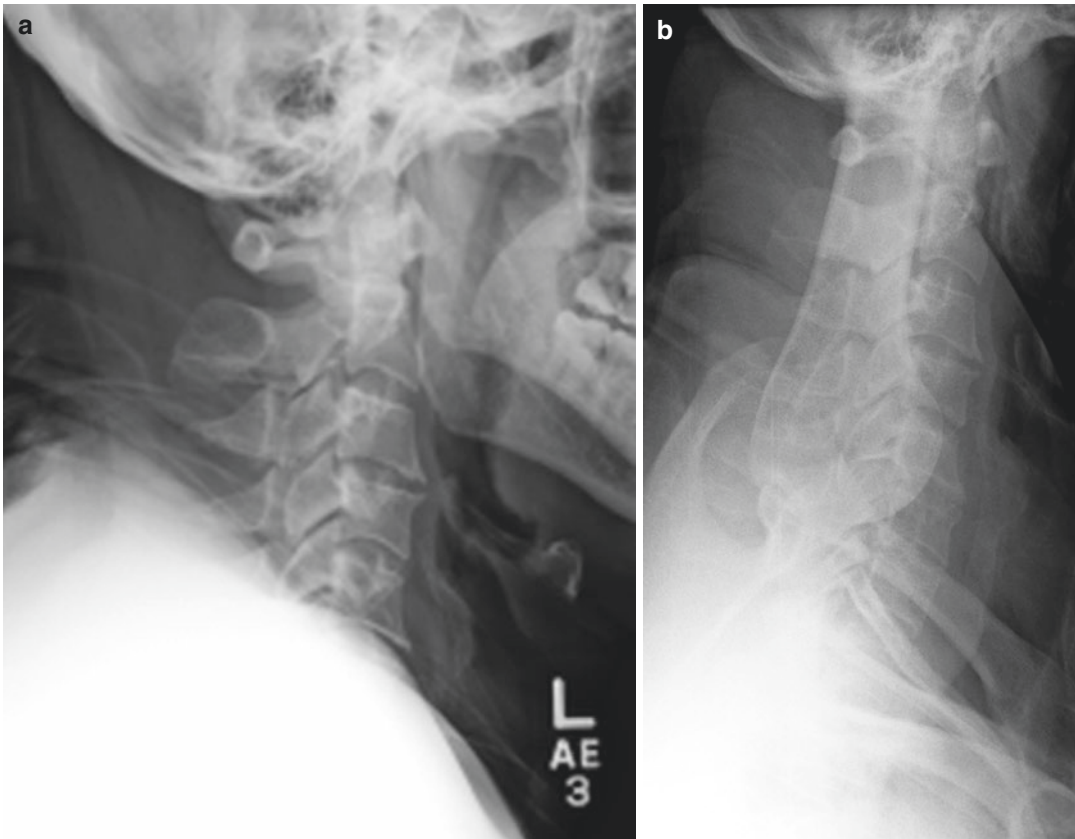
A 47-year-old man who presented with neck pain following a motor vehicle accident. (a) Lateral radiograph of the cervical spine shows inadequate coverage of anatomy. The cervical spine inferior to the C5 level, as
